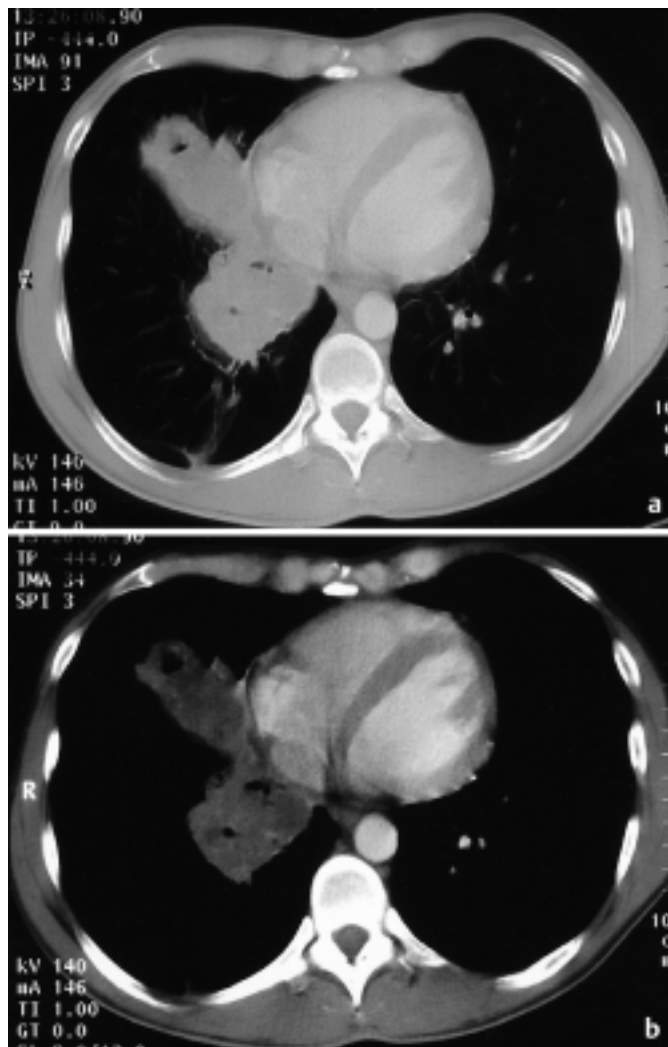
Corresponding contrast-enhanced chest CT scans, obtained at the same level in Fig. 2a) and b) (Fig. 2a: lung window setting; Fig. 2b: mediastinal window setting), demonstrate the extent of alveolar consolidations in the right middle and lower lobes.
